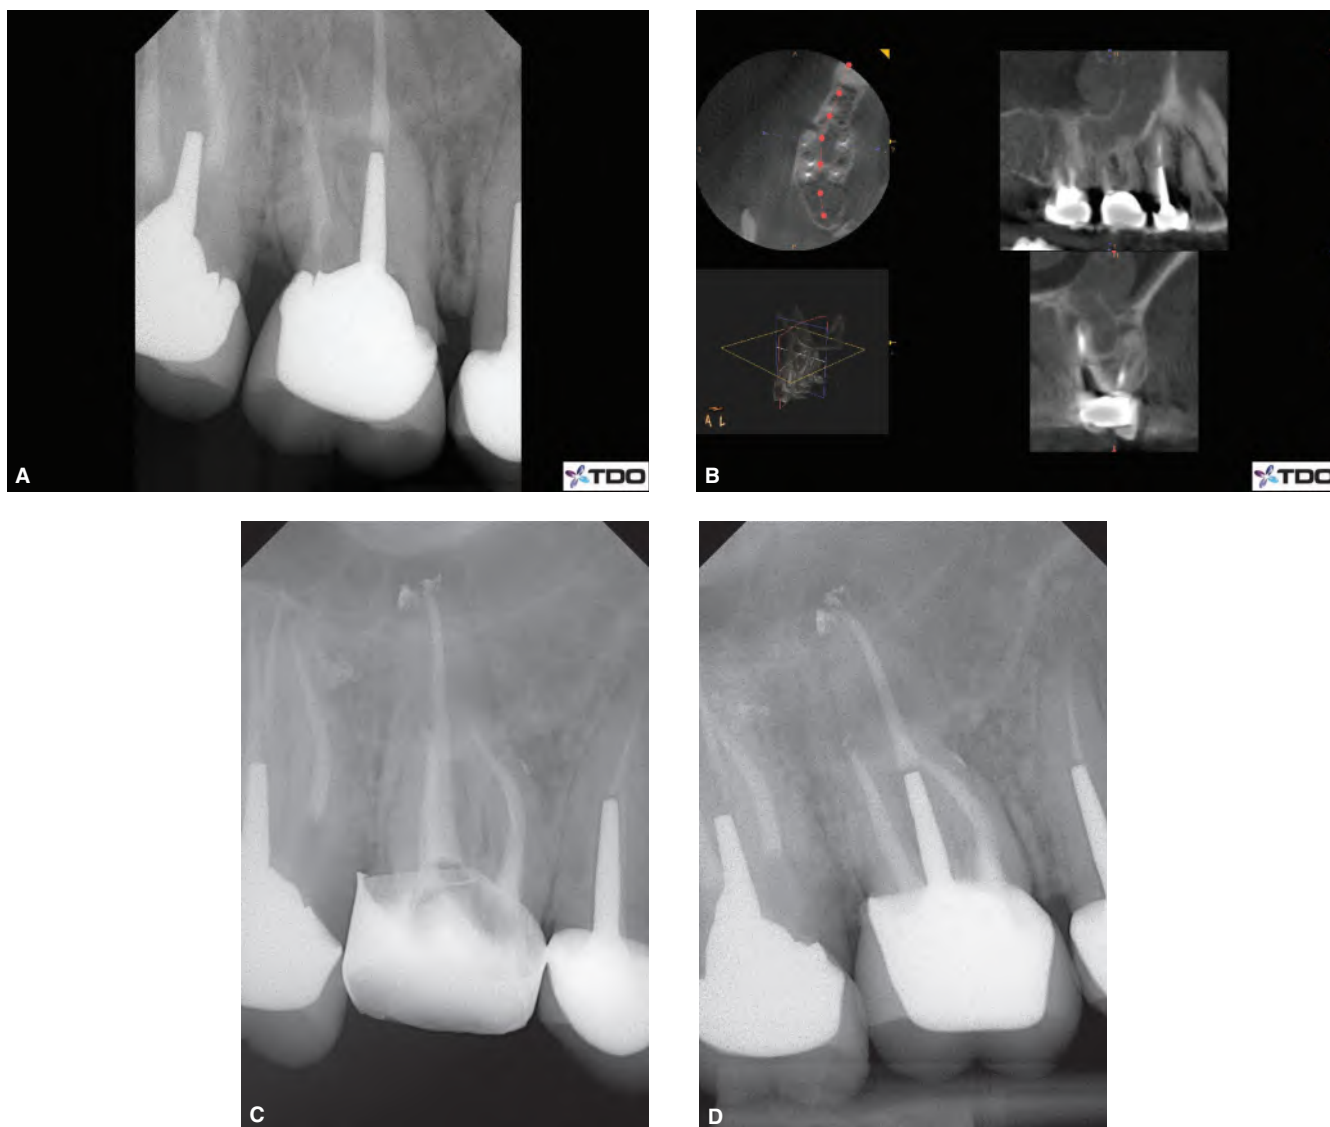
A.* The patient complained of pain on the right first molar. Clinical examination and radiographs were non contributory. *B.* Coronal images from a CBCT showed two periapical lesions on the MB and palatal roots. *C.* Postoperative radiograph after retreatment and 3-D filling. *D.* Pain was relieved. A new restoration was placed two weeks later.
